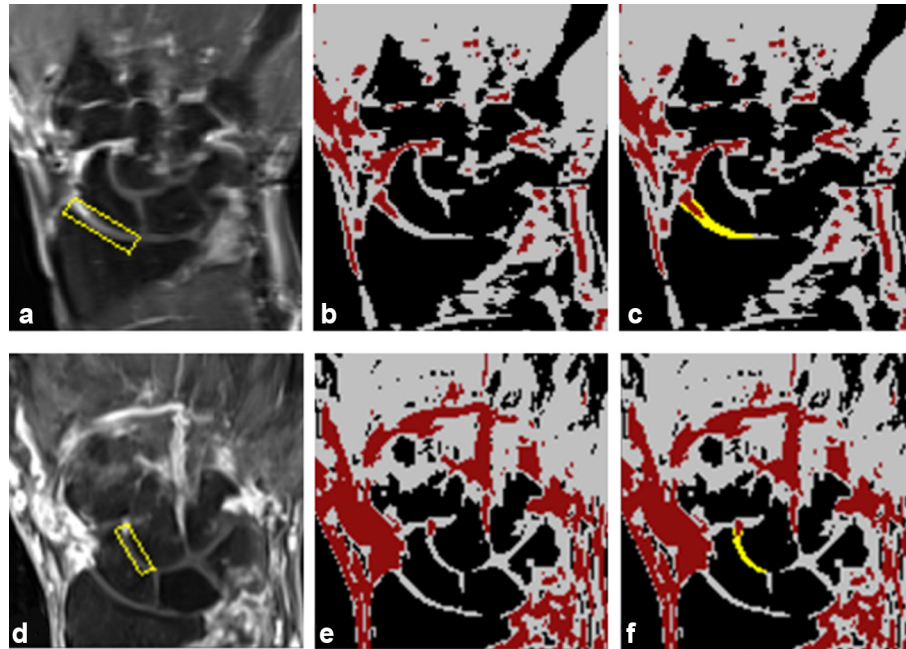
Quantitative measurement of cartilage by in-house developed software. (a), (d) A rectangular ROI placement sized for joint space width of each patient. (b), (e) The whole MR image segmented into three regions; bone (black), cartilage (grey) and synovitis, BME and synovial fluid (red), using two thresholds (T_{lower} - T_{upper}). (c), (f) Calculated cartilage area inside the ROI (yellow). (a), (b), (c) RS joint. (d), (e), (f) SC joint. BME, bone marrow edema; ROI, region of interest; RS, radius-scaphoid joint; SC, scaphoid-capitate joint.
